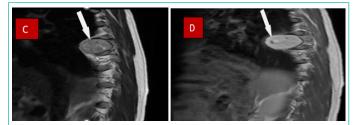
Sagittal slices in T2-weighted (C) and T1-weighted with fat saturation (B) of a spinal MRI before (A) and after the injection of the contrast agent (B).
